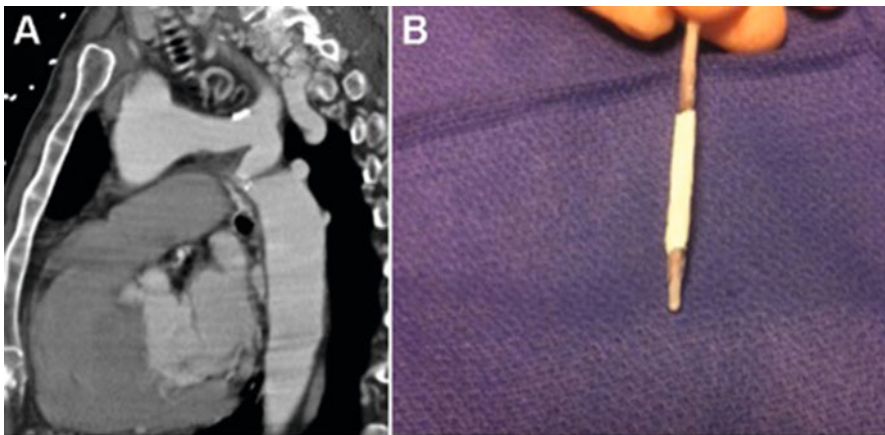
(a) CT angiogram, sagittal view, demonstrating near interruption of the proximal descending thoracic aorta distal to the left subclavian artery in a 55-year-old man with coronary artery disease, multiple prior myocardial infarctions, and evidence of multiple arterial collaterals. (b) Balloon expandable covered stents are preferred to uncovered stents in order to minimize the risk of aortic rupture
